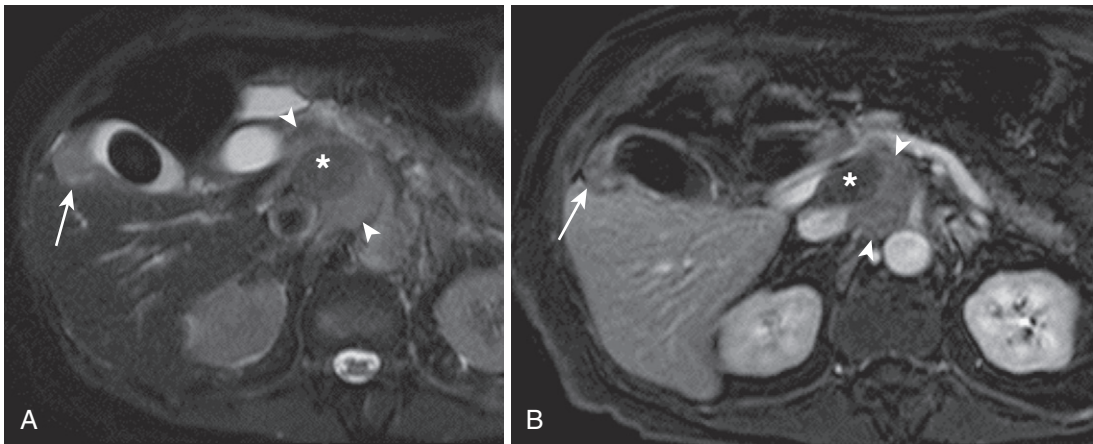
Gallbladder carcinoma. A, Focal gallbladder fundal mural thickening focally obliterating the lumen (*arrow*) on the T2-weighted fat-suppressed image corresponds to the primary tumor in a patient with gallbladder carcinoma (and a gallstone) with metastatic lymphadenopathy (*arrowheads*). B, The postcontrast image shows heterogeneous hypovascular enhancement of both the primary tumor (*arrow*) and the metastatic lymph nodes (*arrowheads*). Note the associated portal venous thrombosis (*asterisk*).
